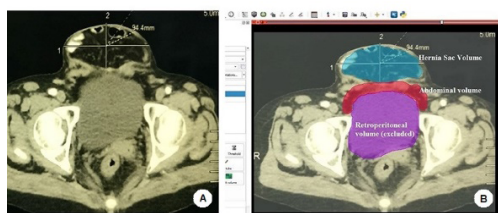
CT-Scan image of 66 years lady with a ventral hernia.
